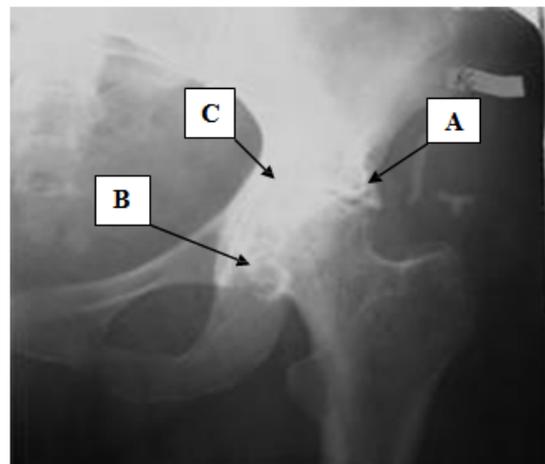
X-ray film of coxarthrosis stage III. A: Marginal osteophytes; B: Marked deformities of the femoral head; C: Complete destruction of the intra-articular cartilage
